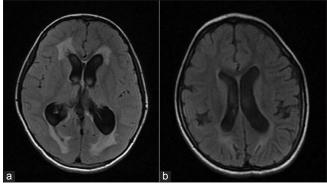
(a and b) T2 FLAIR hyperintensity noted in bilateral peritrigonal region-representating b/l periventricular leukomalacia
